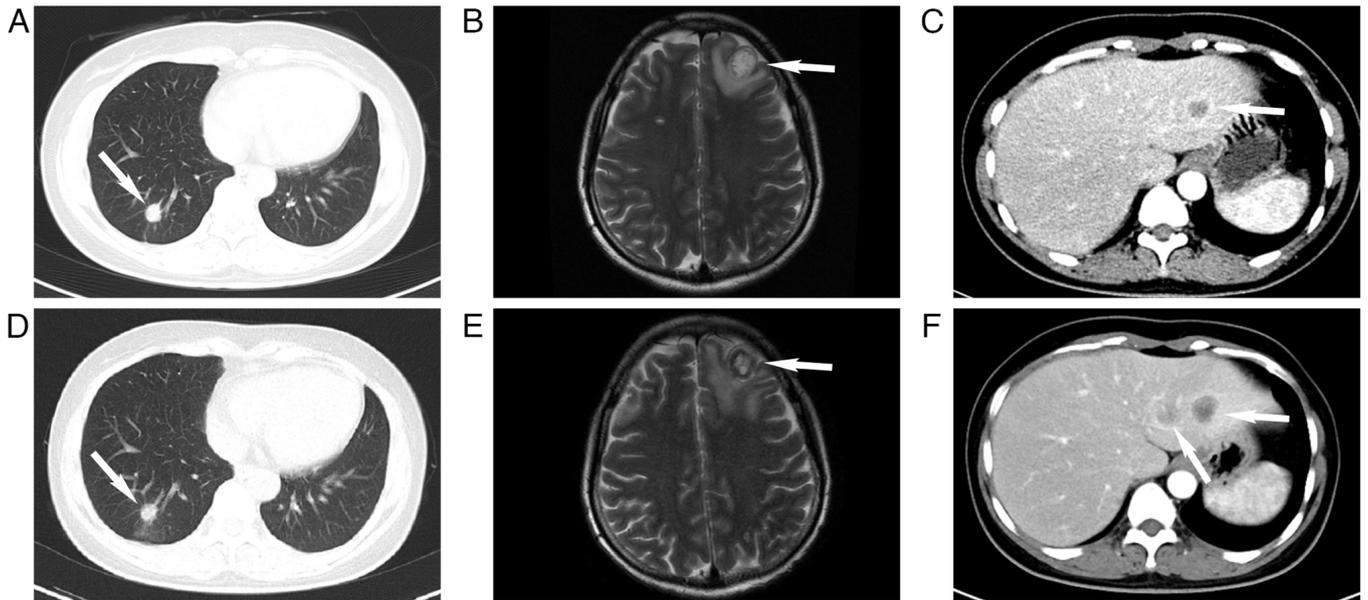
Radiological images of the patient before and after chemoradiotherapy. Before chemotherapy in August 2020: (A) Chest CT image showing the larger nodule, measuring $\sim 15 \times 13$ mm and located in the right lower lung lobe (arrow); this finding was similar to that observed in the patient's scans from March 2020. (B) Brain MR image showing a 17×19 -mm round lesion in the left frontal lobe (arrow). (C) Abdominal CT image revealing a newly developed round low-density lesion in the left lobe of the liver (arrow) measuring ~ 16 mm. After chemotherapy in October 2020: (D) Chest CT image showing the nodule in the right lower lobe of the lung (arrow) showed no changes compared to that before therapy. (E) Brain MR image showing the lesion in the left frontal lobe (arrow) was slightly smaller than before, with surrounding edema. (F) Abdominal CT image showing multiple liver lesions of varying sizes and round shapes (arrow), with the larger lesion measuring ~ 20 mm, and increasing in number and size compared to those before chemotherapy. CT, computed tomography; MR, magnetic resonance.
